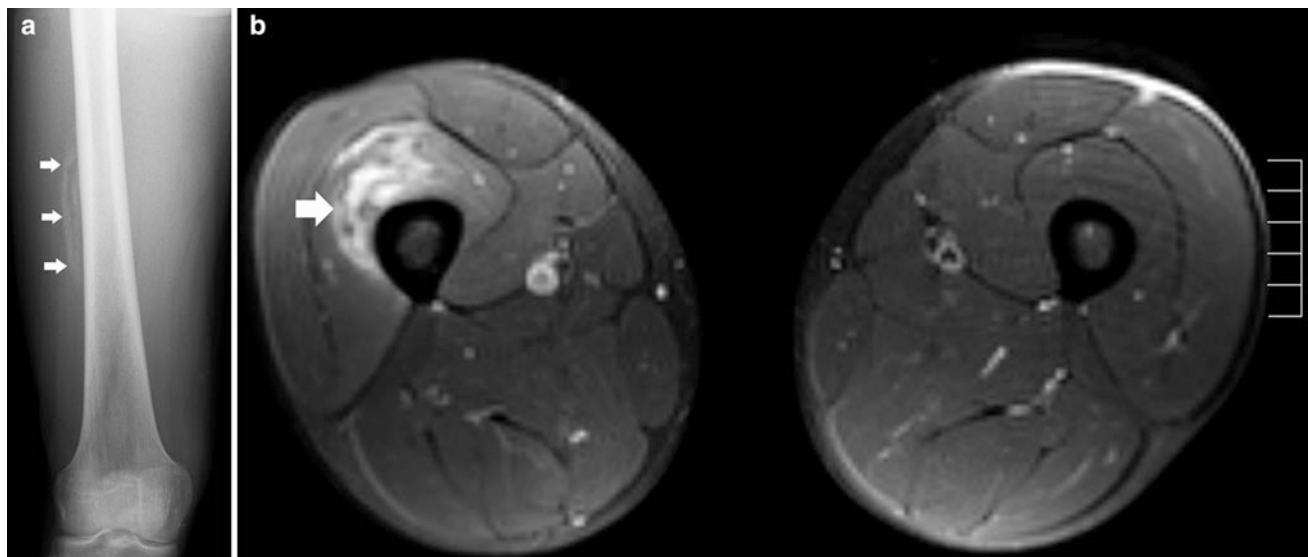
Subacute myositis ossificans of right vastus intermedius muscle. a Plain radiograph of the right femur showing peripheral calcifications adjacent to the lateral aspect of the right femoral diaphysis (*white arrows*) b Axial FS T2-WI showing an irregular
